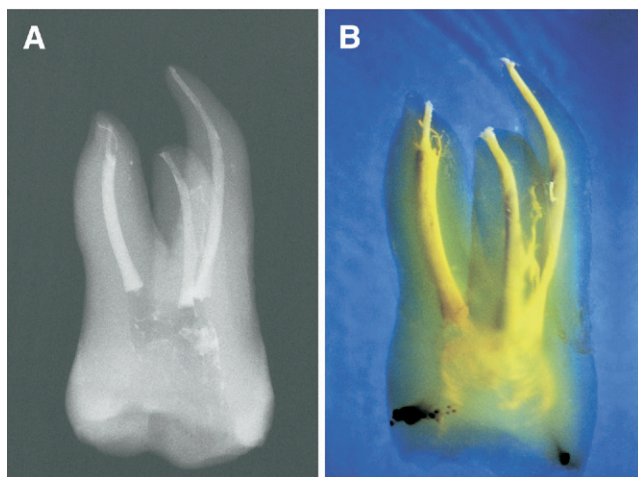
(A) A radiograph and (B) photograph after clearing of a maxillary molar filled with the vertical compaction with the apical backfilling technique (VCAB) using AH Plus that show either a homogeneous filling of main canals as well the partial filling of apical lateral canals (arrows) in the mesial-buccal root; (C) a radiograph and (D) photograph after clearing of a mandibular molar filled with the vertical compaction the apical backfilling technique (VCAB) using PCS (EWT); (E) a photograph after clearing of the apical third of the distal root of the previous teeth, showing two apical lateral canals filled with sealer (arrows); (F) photograph after clearing of the apical and middle third of a main root canal filled with VCAB using PCS (EWT), showing either a great void (white arrow) at the limit between the cold-compacted GT Tulsa plug and the backfilling as well other voids on the surface of the backfilled volume (black arrows); (G) a photograph after clearing of the middle third of a main root canal filled with VCAB using PCS (EWT), showing a circular void (white asterisk), two lateral canals partially filled with sealer (black asterisks), and finally two elongated spaces between the filling and the canal walls (black arrows); (H) photograph after clearing of the coronal third of a main root canal filled with VCAB using PCS (EWT), showing an accessory communicating canal (black asterisk) and an elongated space between the filling and the canal wall (black arrow).
